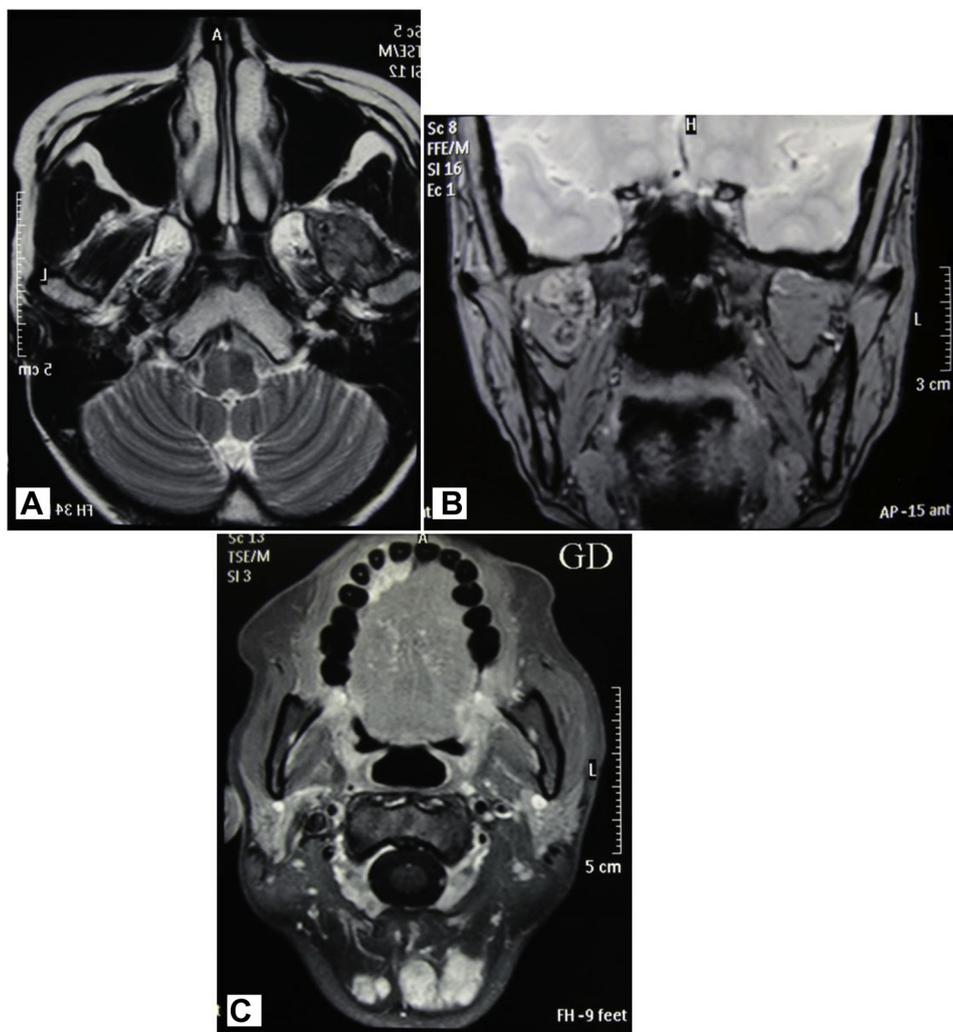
Magnetic resonance images (MRI) of oral and maxilla. (A) Axial T2-weighted MRI of maxilla. (B) Coronal T2-weighted MRI of maxilla. (C) Contrast-enhanced fat-suppressed T1-weighted MRI of maxilla.
